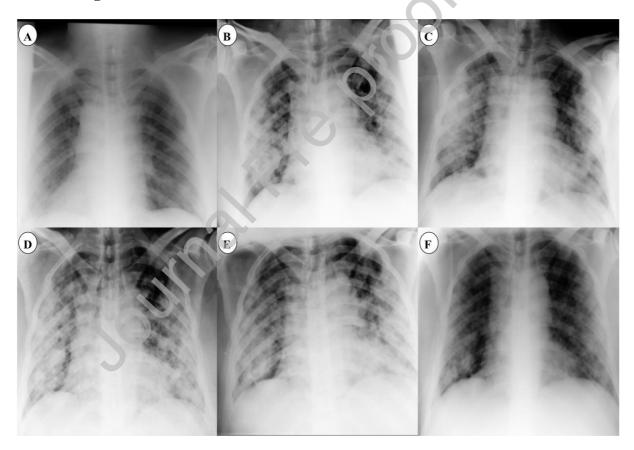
Chest X-ray of the patient during hospitalization. (a, b, and c) Progression of lower and upper lobe infiltration. (d, e, and f) Recovery of infiltration after tocilizumab administration.
